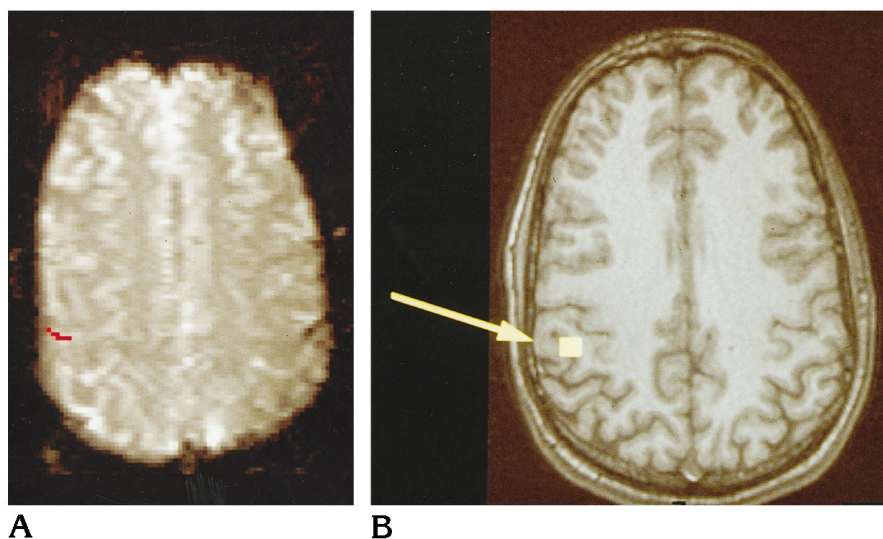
Right index finger stimulation (same subject as in Figure 3): functional MR imaging (A) and magnetic source imaging (B). Pixels identified as activated by functional MR imaging are overlaid on an acquired gradient-echo echo-planar image (echo time, 60; flip angle, 90°; FOV, 40 × 20 cm; matrix, 128 × 128). Magnetic source imaging locations are overlaid on a spoiled gradient-echo MR image (35/5) (flip angle, 30°; section thickness, 1.5 mm).
